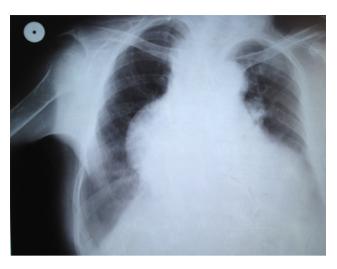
Chest X-ray showed severe enlargement of the mediastinum.
